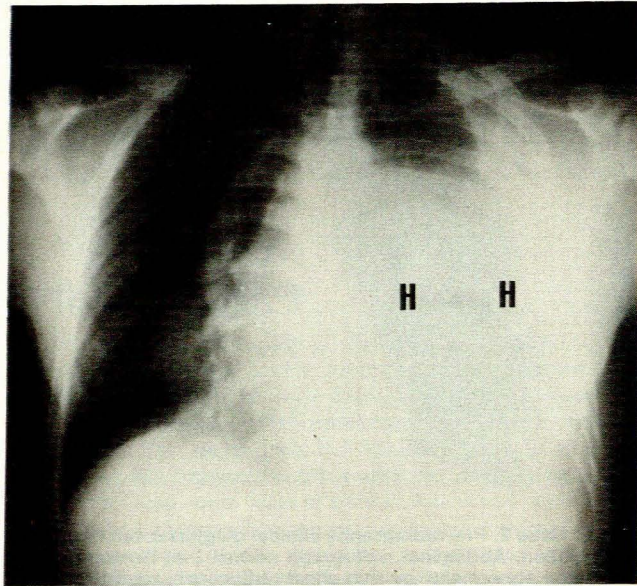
Case 3. Pre-radiography clinical diagnosis: pancreatitis. Post-radiography diagnosis: strangulated colonic hernia. The patient died before operation. Radiograph (top left) shows large pleural effusion with gas-fluid collection representing the hernia (H). Bottom: strangulated hernia (H) with colon (C) dilated proximal to it; normal stomach gas bubble (S). Top right: typical barium enema appearance of obstructed colonic herniation through diaphragm (arrows).
